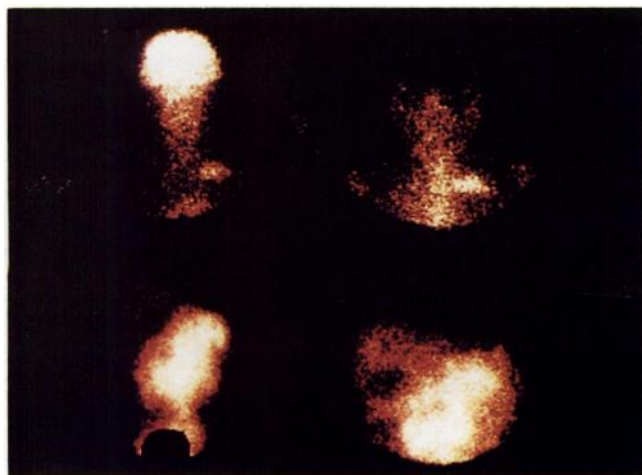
Biodistribution of FDG (left) and ⁶⁷Ga (right) in a patient with supraclavicular (top row) and retroperitoneal (bottom row) localizations of non-Hodgkin's lymphoma.
